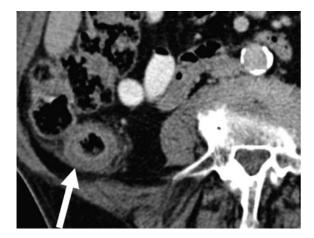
Mucosal and mural infarction in an 83-year-old male with coronary artery disease and cardiac failure, contrastenhanced CT. Wall thickening, high attenuation of the mucosa caused by hemorrhage and/or contrast enhancement due to reperfusion, and submucosal edema in the ascending colon (*arrow*). The bowel ischemia is secondary to hypoperfusion. The patient fully recovered
